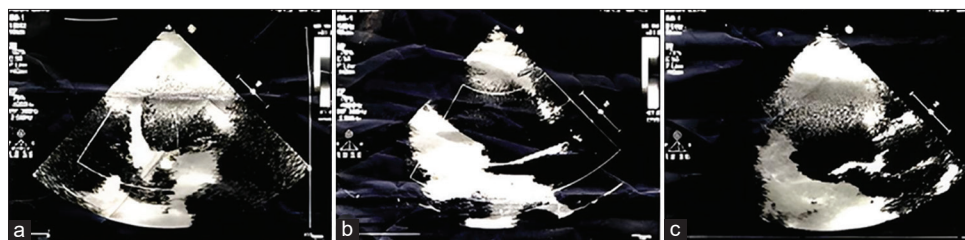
Echocardiography images (a) and (b) show significant left ventricular dysfunction, while image (c) demonstrates an ejection fraction of 22–25%
